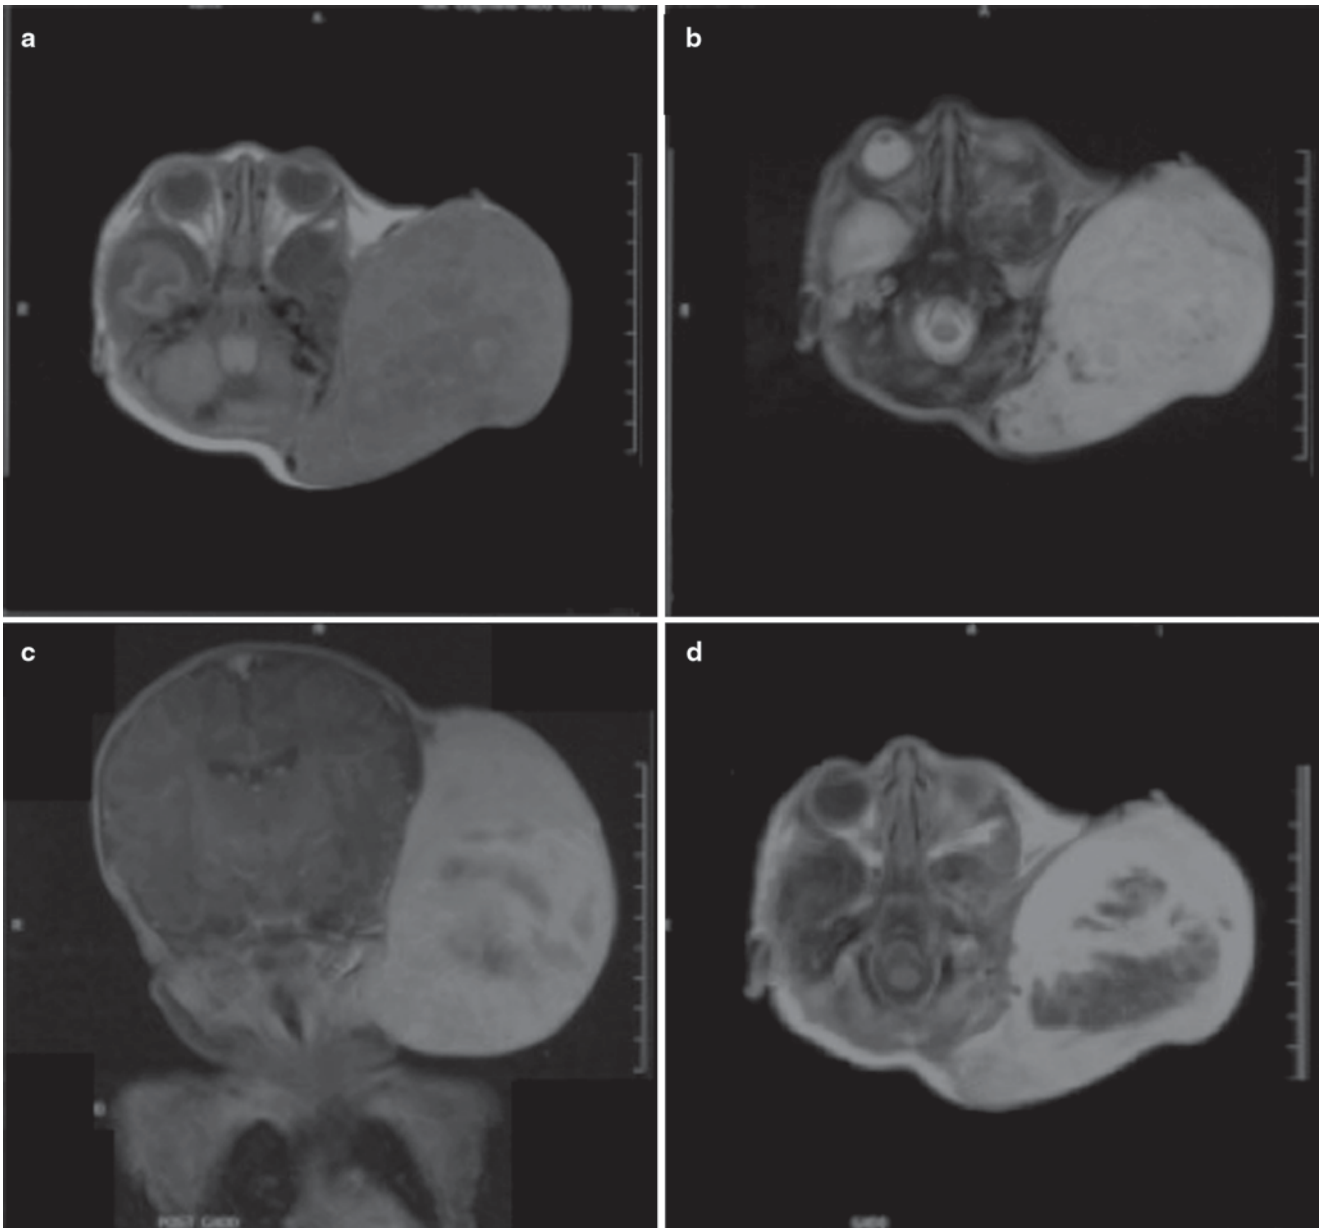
An axial CT scan showing a left cervical fetal rhabdomyoma in a male newborn infant. T1 weighted-images (a), the tumor is diffusely homogenous to muscle with regular margins; T2 weighted-images
